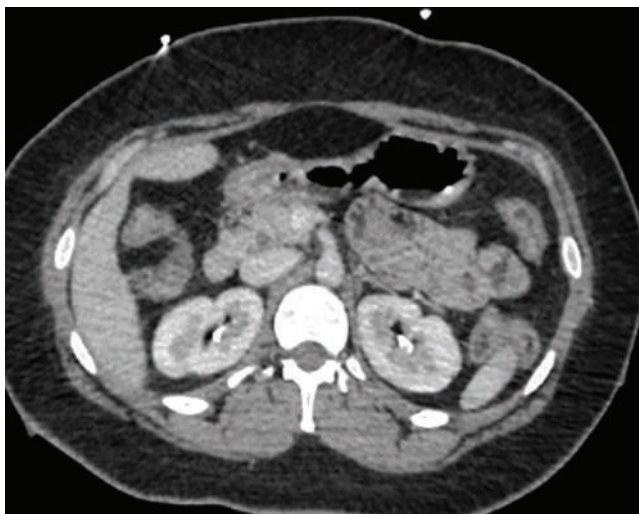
Initial axial trauma computed tomography (CT) image demonstrating no pathological findings.
